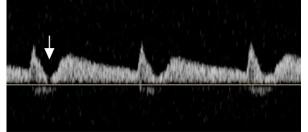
Pulsed-wave Doppler ultrasonogram of the left vertebral artery shows a "bunny" waveform: a midsystolic dip (arrow), a first systolic peak (the rabbit's ears), and a second blunted systolic peak (the rabbit's rump), suggesting left subclavian stenosis.
